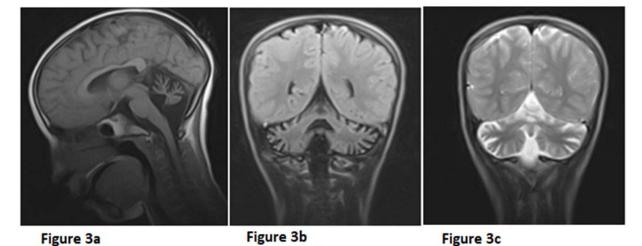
Sag SE T1 (a), Cor FLAIR (b) and Cor FSE T2 showed diffuse cerebellar atrophy involving vermis and both cerebellar hemispheres.
